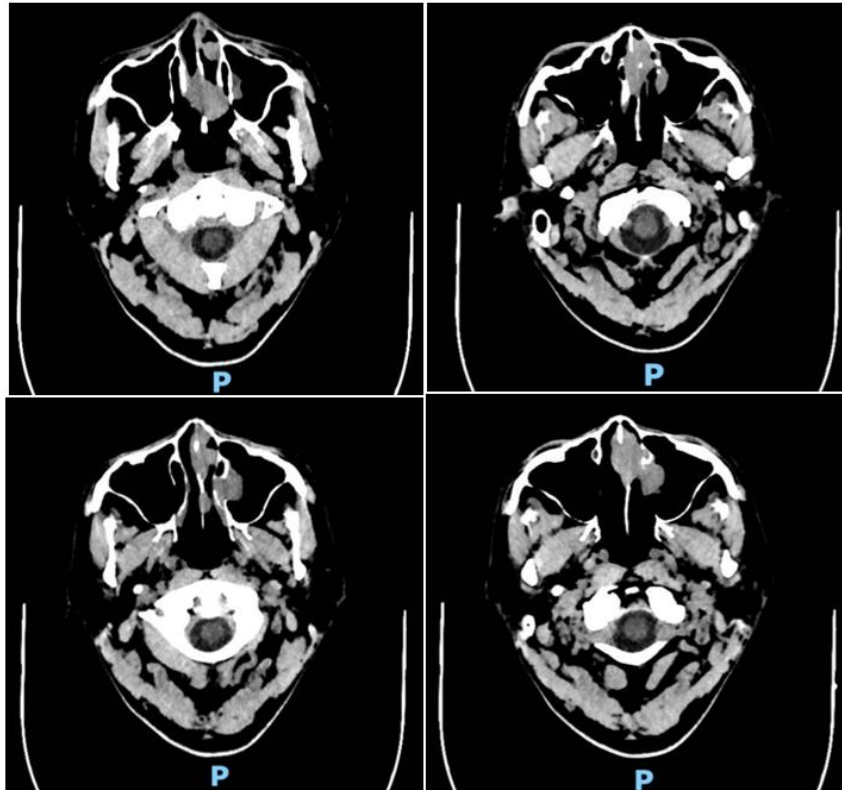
CT scan of the nose and paranasal sinuses without contrast 2mm axial slice
